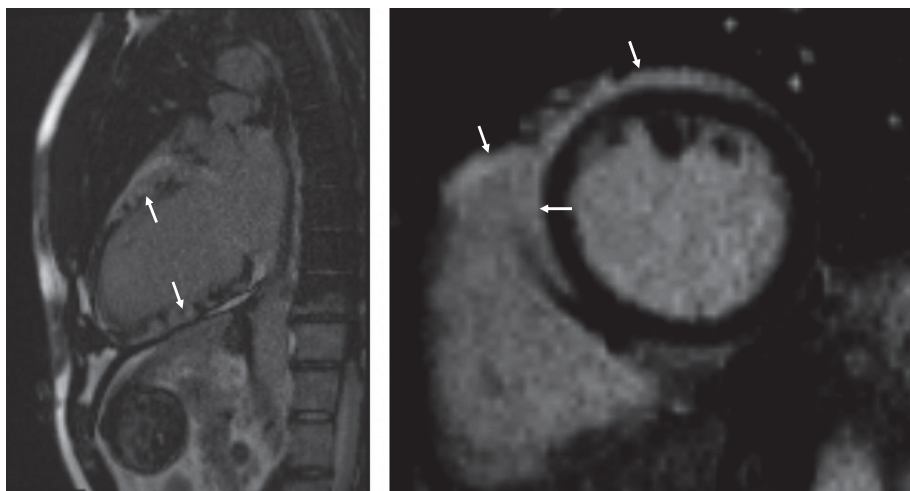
Cardiac magnetic resonance imaging showing abnormal late gadolinium enhancement (LGE). Left panel: long-axis slice where LGE is present in a widespread, patchy, mid-to-epicardial fashion (arrows). Right panel: short-axis slice showing confluent epicardial LGE extending into the interventricular junction and right ventricle (arrows).
